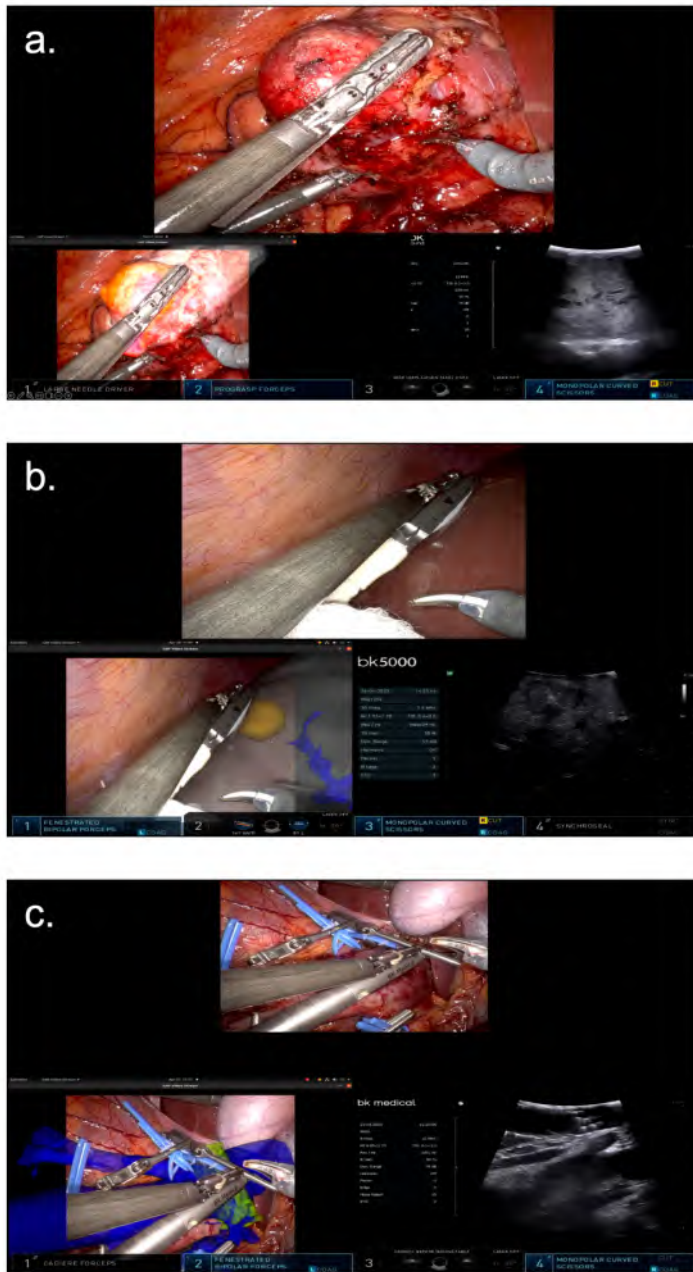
Robotic console view during all 3 live cases. The A.R. stream with instrument segmentation is presented in the lower left TilePro™ window, the lower right window depicts the echography image depicting respectively the renal tumor (a), the liver metastasis (b) and the hyperechogenic vascular stent (c). a) Tumor identification during RAPN. b) Ultrasound detection of an endophytic colorectal liver metastasis during robotic liver resection. c) Robotic migrated endovascular stent removal, placed for nutcracker syndrome.
